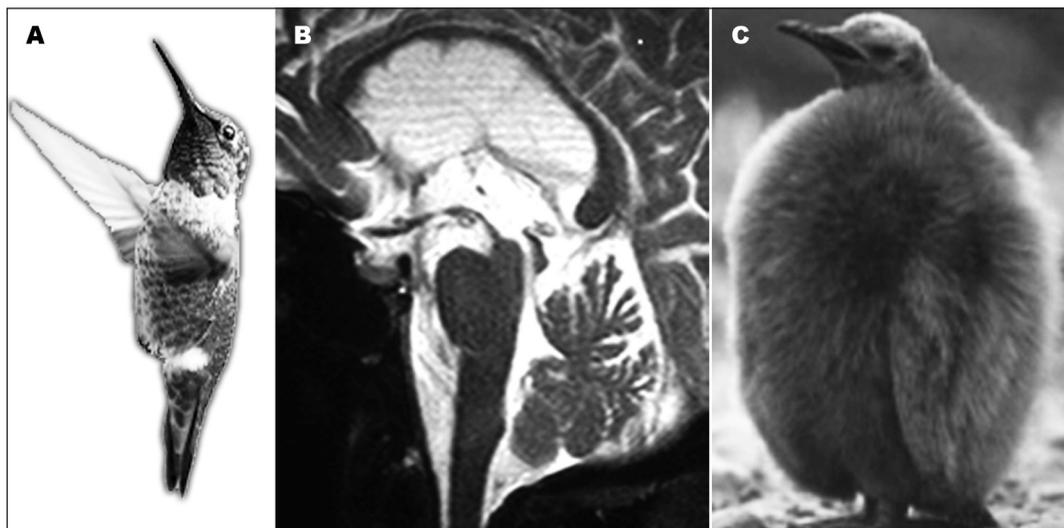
Brain T2-weighted sagittal MR scan from a PSP patient [B]. Notice the relative atrophy of the mesencephalon as compared with the pons. The brain stem in this case resembles a hummingbird [A] or a king penguin [C].
